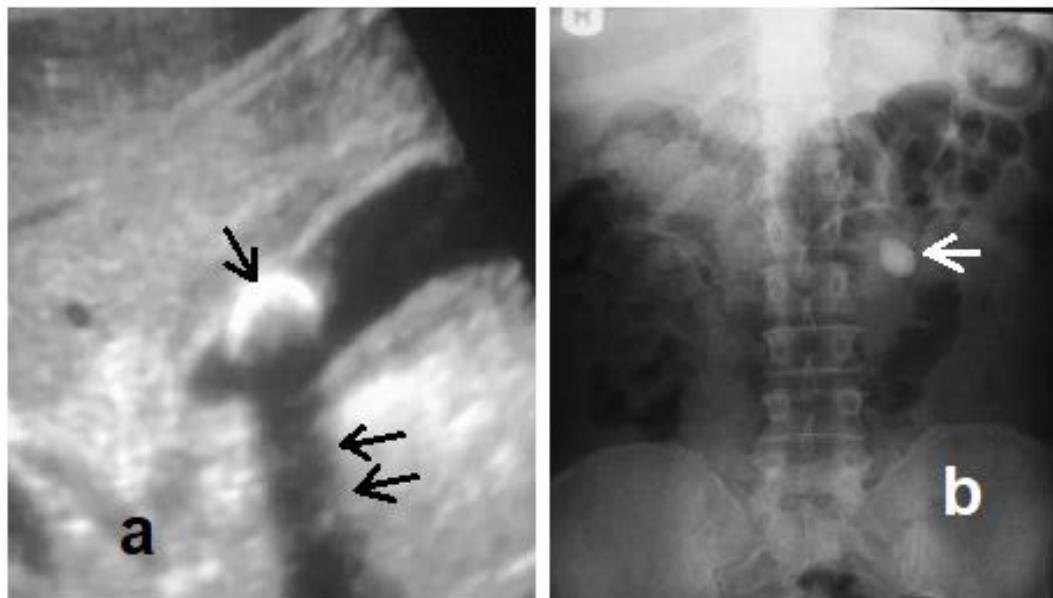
a. Sonogram showing gallstone (arrow) within the gall bladder casting distal acoustic shadow (double arrows). b. Radiograph showing left renal calculus (white arrow) causing acute abdomen.
